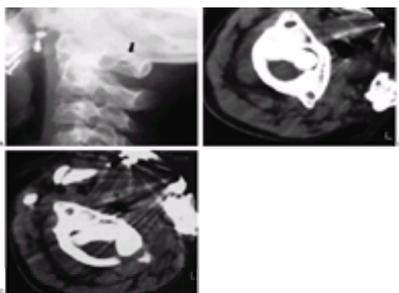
Radiographic findings in atlantoaxial rotary subluxation. A: The lateral cervical spinal radiograph. The posterior arches fail to superimpose because of the head tilt (arrow). B and C: Dynamic computed tomography scans in a 9-year-old girl with a fixed atlantoaxial rotary displacement, with the head maximally rotated to the left (B), and the head maximally rotated to the right (C), which, in this case, does not reach the midline. The ring of C1 is still in the exact relation to the odontoid as in B, indicating a fixed displacement.
